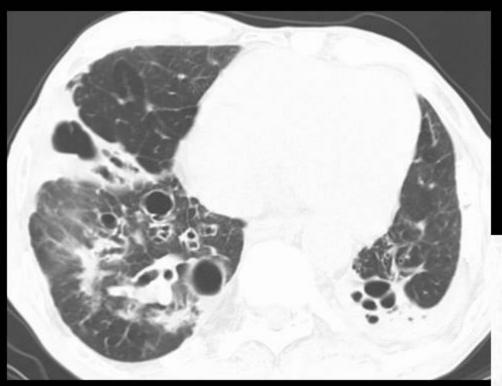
Man, 62 years old, with hemoptysis and history of pulmonary tuberculosis. Thoracic CT shows bilateral traction bronchiectasis (lower and middle lobes), left paquipleuritis—and loss of volume of the left lung with ipsilateral mediastinal shift.
